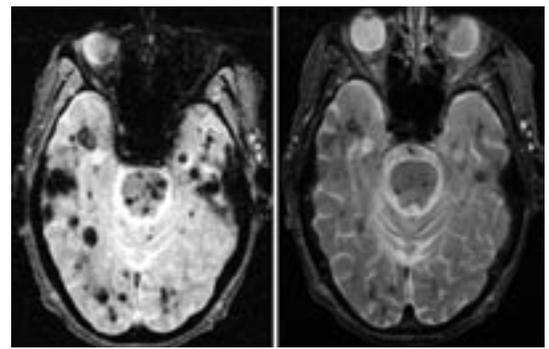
MRI scans of the brain, including gradient echo sequences (left) and standard T2-weighted images (right) of a patient with multiple intracranial CMs. These images are characteristic of the familial form. The gradient echo sequence (left) allows better visualization of the individual lesions than the T2-weighted sequence (right).
